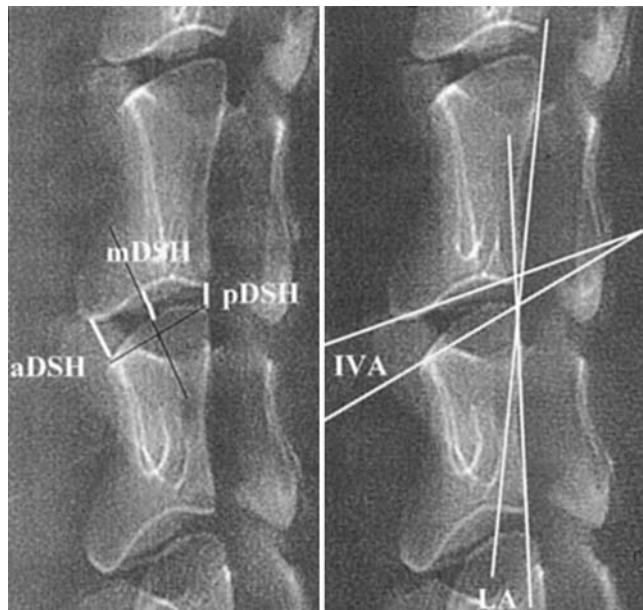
Radiographic measurements. *Left:* Anterior DSH (aDSH), posterior DSH (pDSH), and middle DSH (mDSH). *Right:* The IVA and LA.
